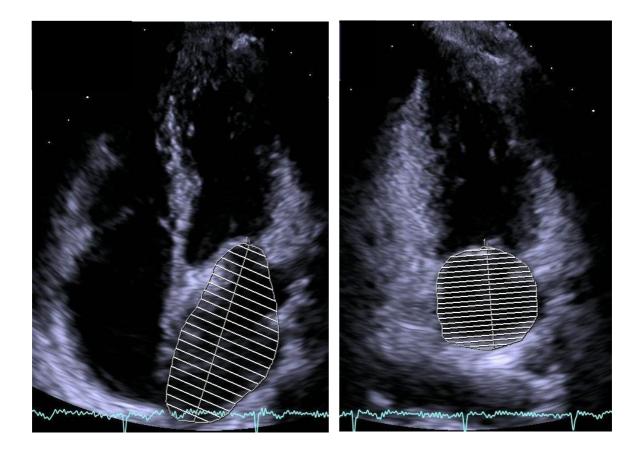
Echocardiographic images showing the measurement of left atrial area and long axis lenght by planimetry in the apical four-chamber (left image) and two-chamber (right image) views at left ventricular end systole (maximum left atrial dimensions). These measurements were used to calculate left atrial volume indexed to body surface area using the area-length method.
